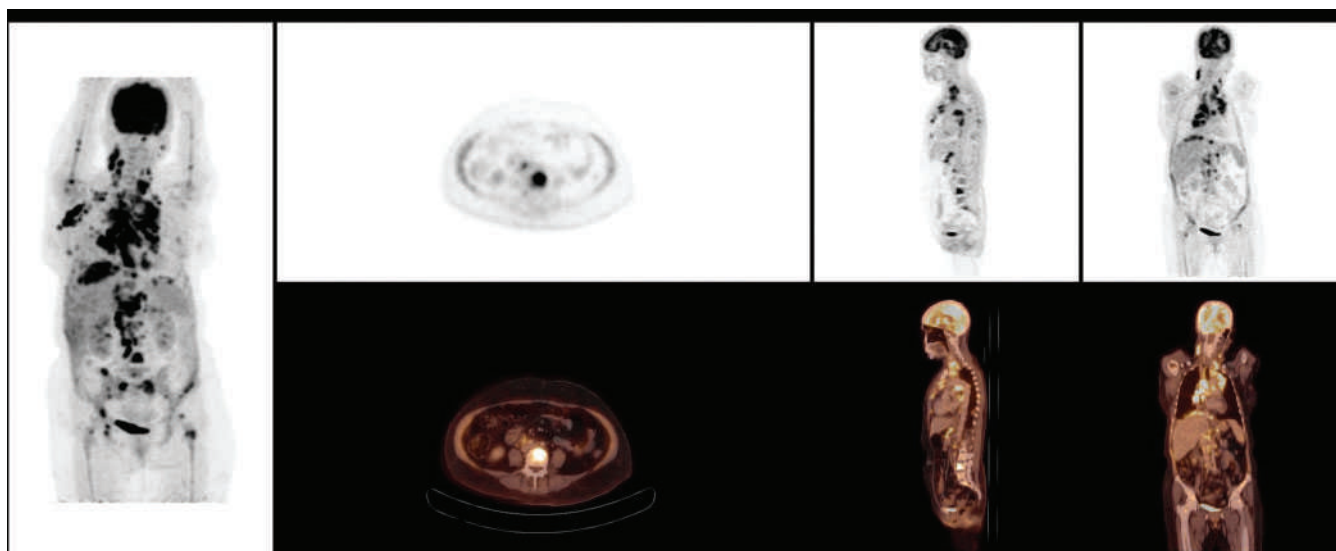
Fludeoxyglucose-positron emission tomography/CT shows multiple hypermetabolic bone lesions involving mainly the axial skeleton, the ribs, the proximal humeri and both femurs. Bone marrow biopsy was negative in this patient.
